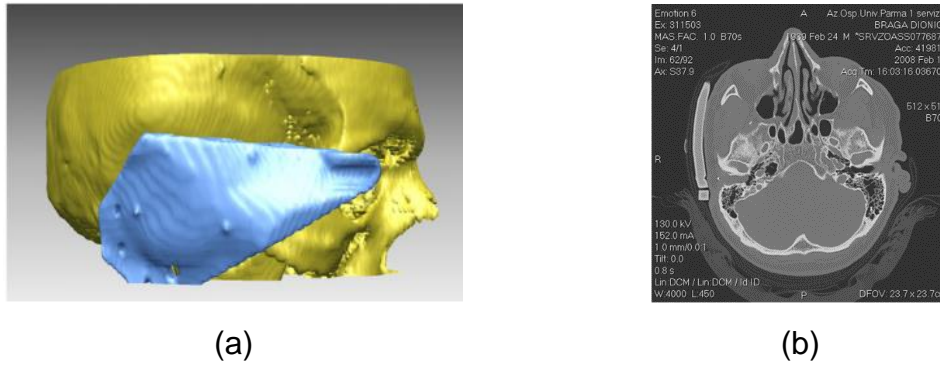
(a) Virtual environment versus (b) X-ray film [23].
